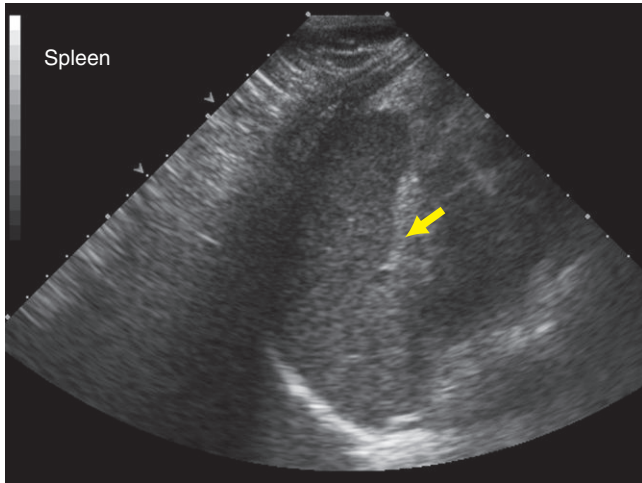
Ultrasound of the spleen (arrow) was obtained.
